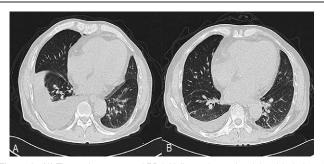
(A) The patient restarted PD initially, and massive right-sided pleural effusion and compressive atelectasis were subsequently noted on HRCT. (B) A small amount of right-sided pleural effusion was found on HRCT when the patient resumed PD the second time. HRCT=high-resolution computed tomography.
